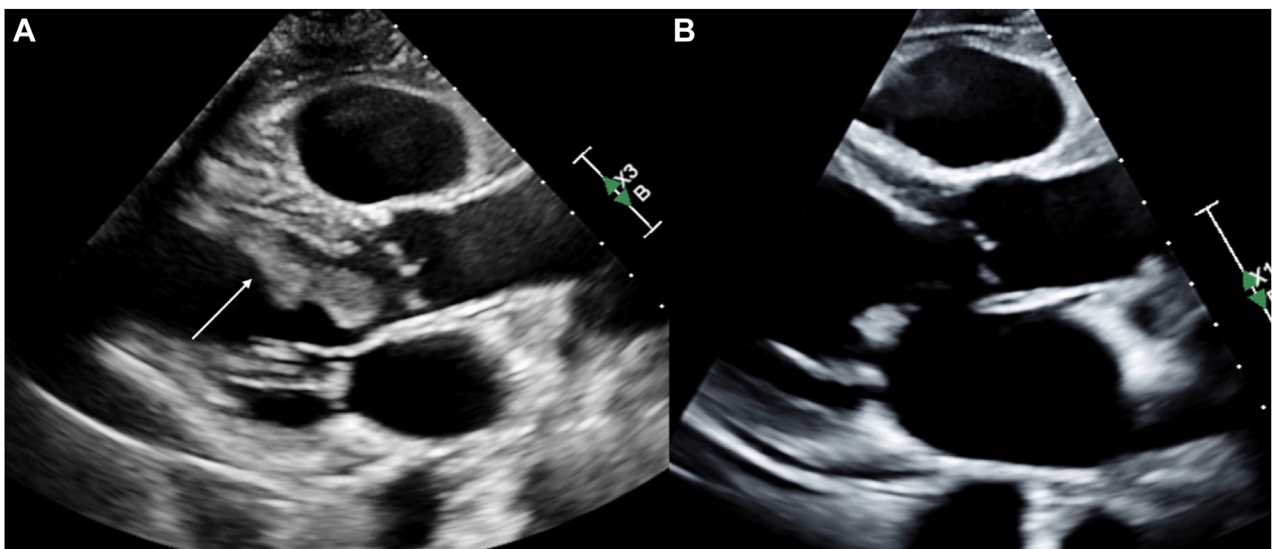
Two-dimensional TTE, parasternal long-axis views, end-diastolic phase, obtained 1 month following initial diagnosis demonstrates the mass (*arrow*) attached to the septum and extending into the left ventricular outflow tract prior to targeted molecular therapy treatment (A) and resolution of the mass posttreatment (B).
